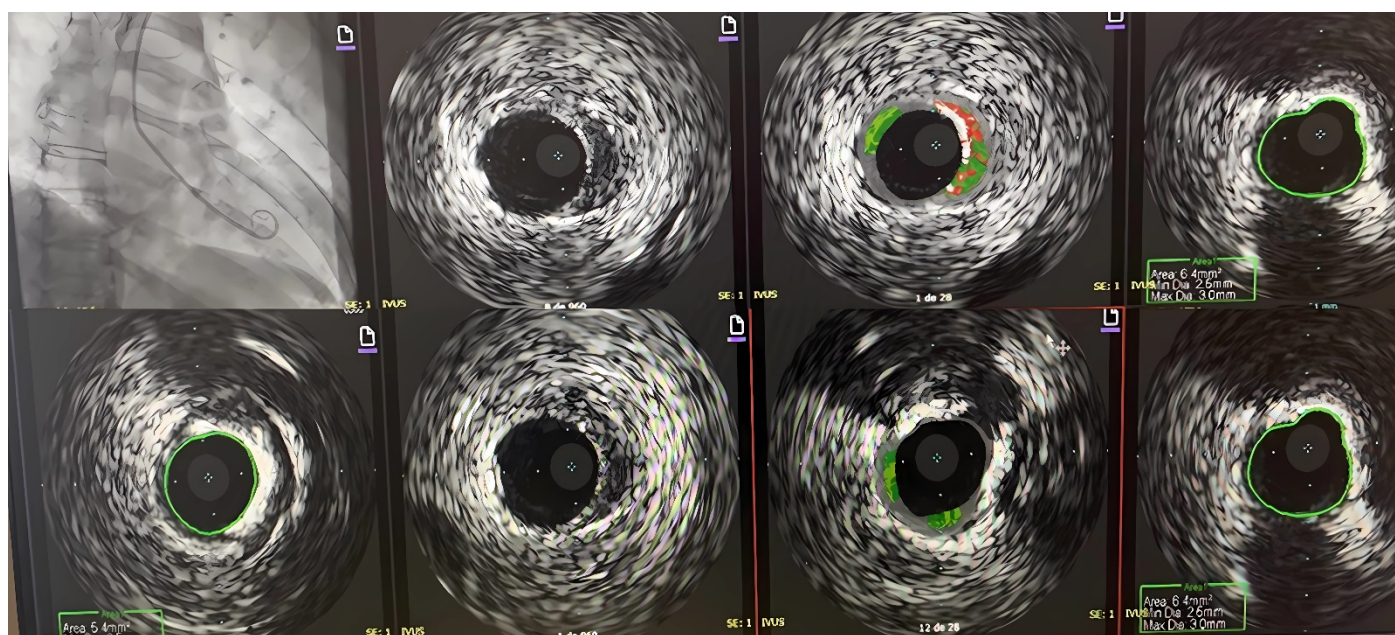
Coronary angiography and intravascular ultrasound (IVUS) revealed non-obstructive coronary artery disease. Mild calcified stenosis (30–40%) is observed in the proximal left anterior descending artery, with a minimal luminal area of 5.4 mm².
